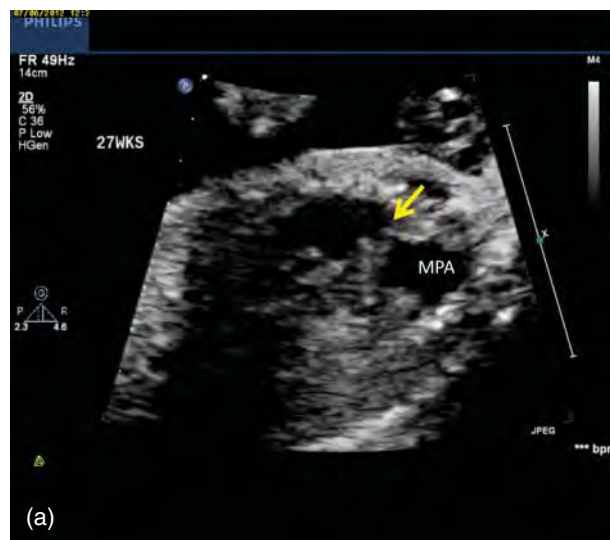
Fetal echocardiogram of a fetus at 27 weeks' gestation with tetralogy of Fallot and absent pulmonary valve. This fetus developed hydrops as evidenced by increased skin thickness, abnormal ductus venosus, and increased cardiothoracic ratio (not shown) and ultimately had intrauterine demise. (a) The dysplastic pulmonary valve (yellow arrow) and dilated main pulmonary artery (MPA) can be seen in this two-dimensional (2D) view. (b) 2D and color view showing dilated right (RPA) and left (LPA) pulmonary artery branches characteristic of absent pulmonary valve syndrome. (c) Doppler evaluation of the pulmonary valve demonstrating significant pulmonary valve regurgitation (blue arrow; positive wave, above the baseline) and pulmonary valve stenosis (yellow arrow; negative wave, below the baseline).
